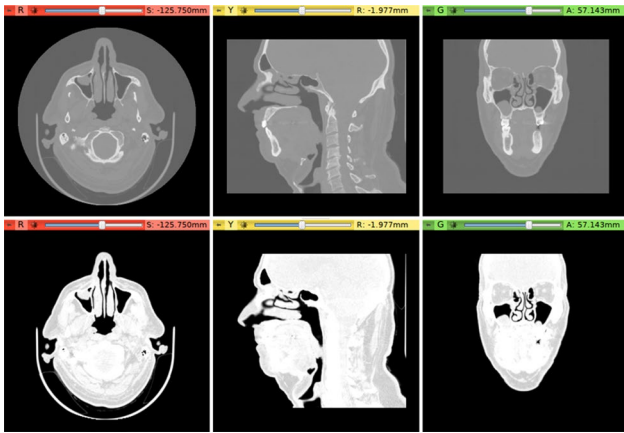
Example of the raw CT images rendered on a *grayscale lookup table*, with a linear scale (*top*) and with emphasis on air in the CT volume (*bottom*)
